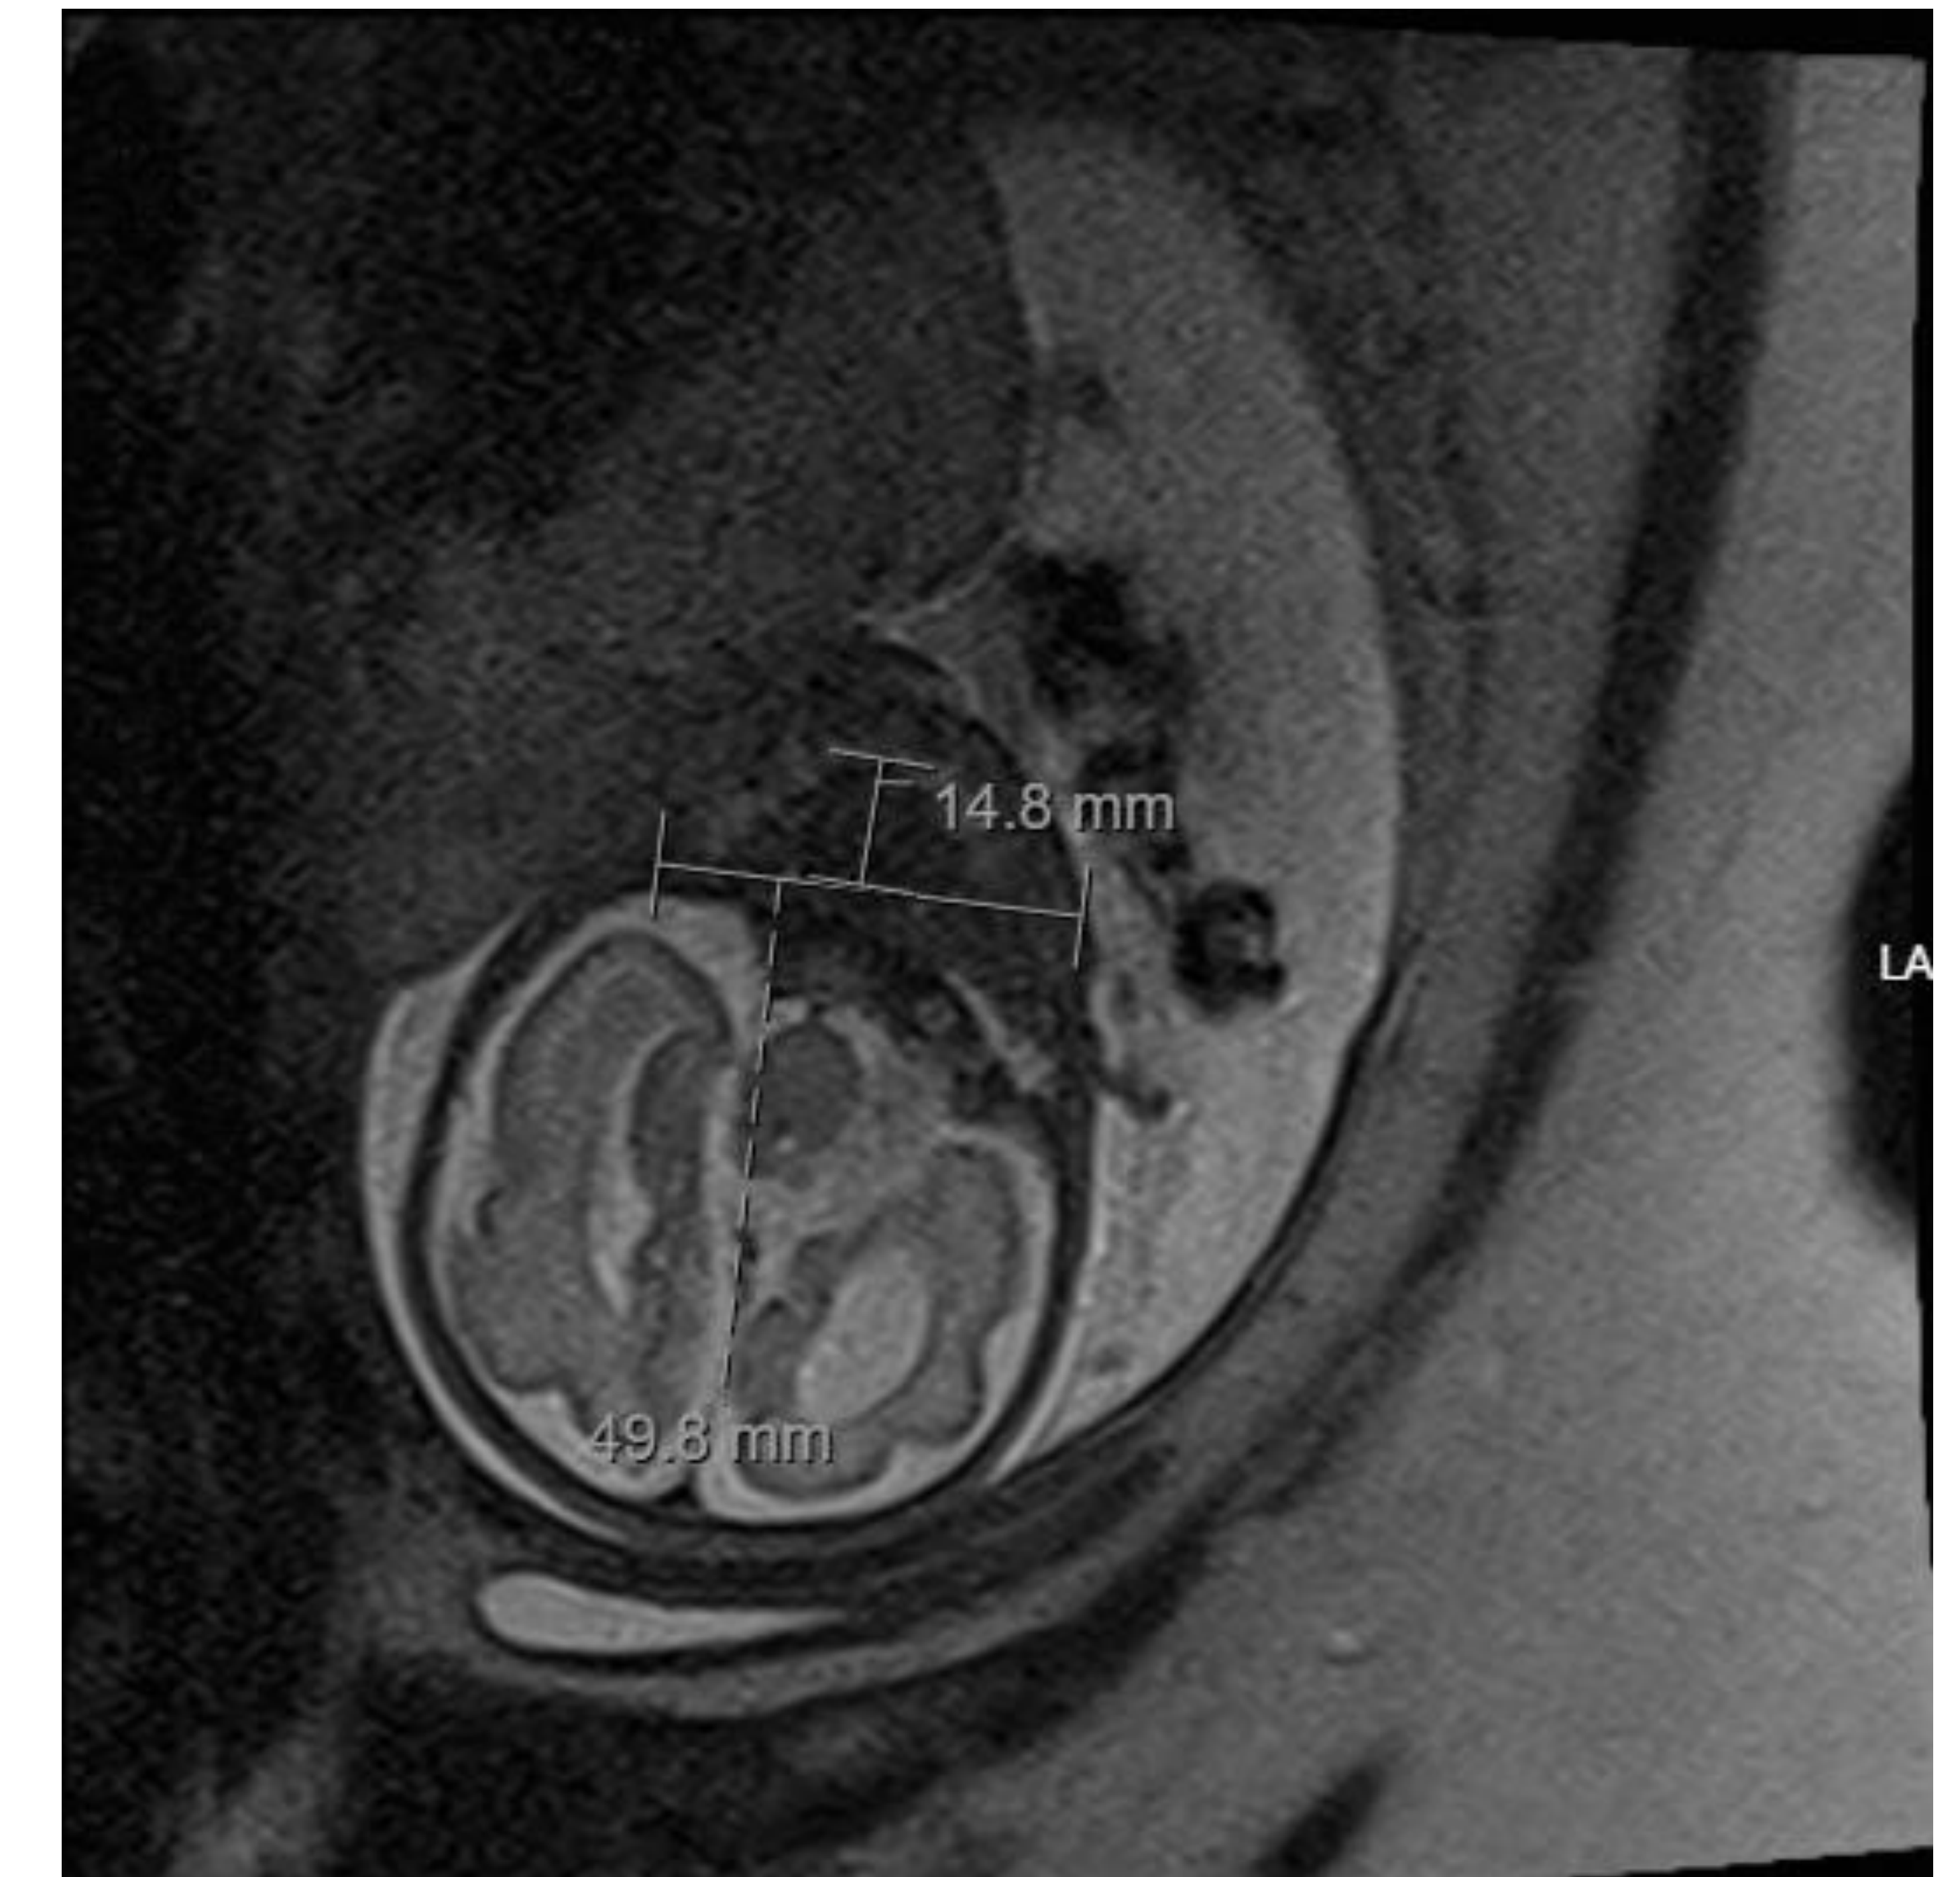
Fetal MRI demonstrating a jaw index of 18. The jaw index is measured by AP mandibular distance/biparietal distance * 100, and an index of <23 is 100% sensitive and 98% specific for micrognathia
